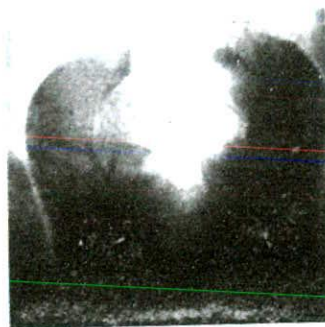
X-ray photograph of the pelvis showing a dead foetus. The bones of the cranial vault show loss of alignment and overlapping (Spalding's sign).
